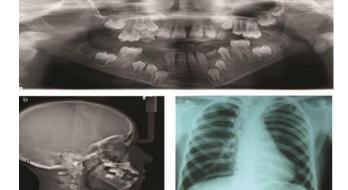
(a) Digital OPG showing hypoplastic condyle and coronoid processes and flattening of glenoid fossa and articular eminence (b) lateral cephalograph shows block vertebrae with C2 and C3 (c) Chest radiograph reveals crowding of ribs on the left side and scoliosis of vertebral column
